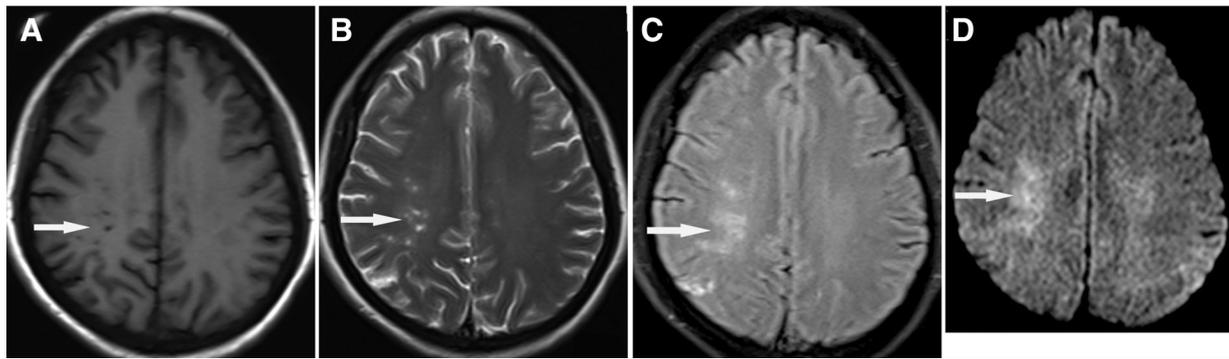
MRI findings demonstrated cerebral infarction in centrum semiovale. (A and B) Axial T1-weighted image showing marked multiple hypointensity (white arrow) and T2-weighted image showing marked multiple hyperintensity (white arrow) in centrum semiovale. (C and D) Fluid-attenuated inversion recovery sequence and diffusion-weighted imaging, axial MRI demonstrating hyperintensity (white arrow) in centrum semiovale.
